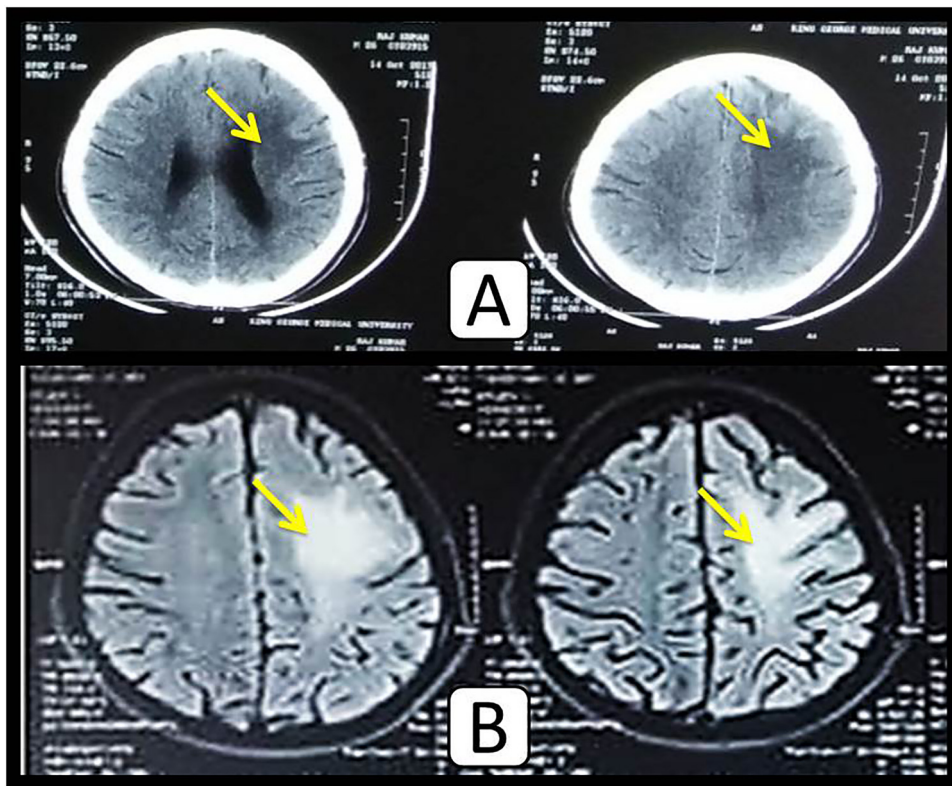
CT scan of brain showing hypodense lesion in the left fronto-parietal region (2A) and MRI of the brain showing white matter hyperintensity in the periventricular area on the diffusion weighted images over left fronto-parietal region (2B).
